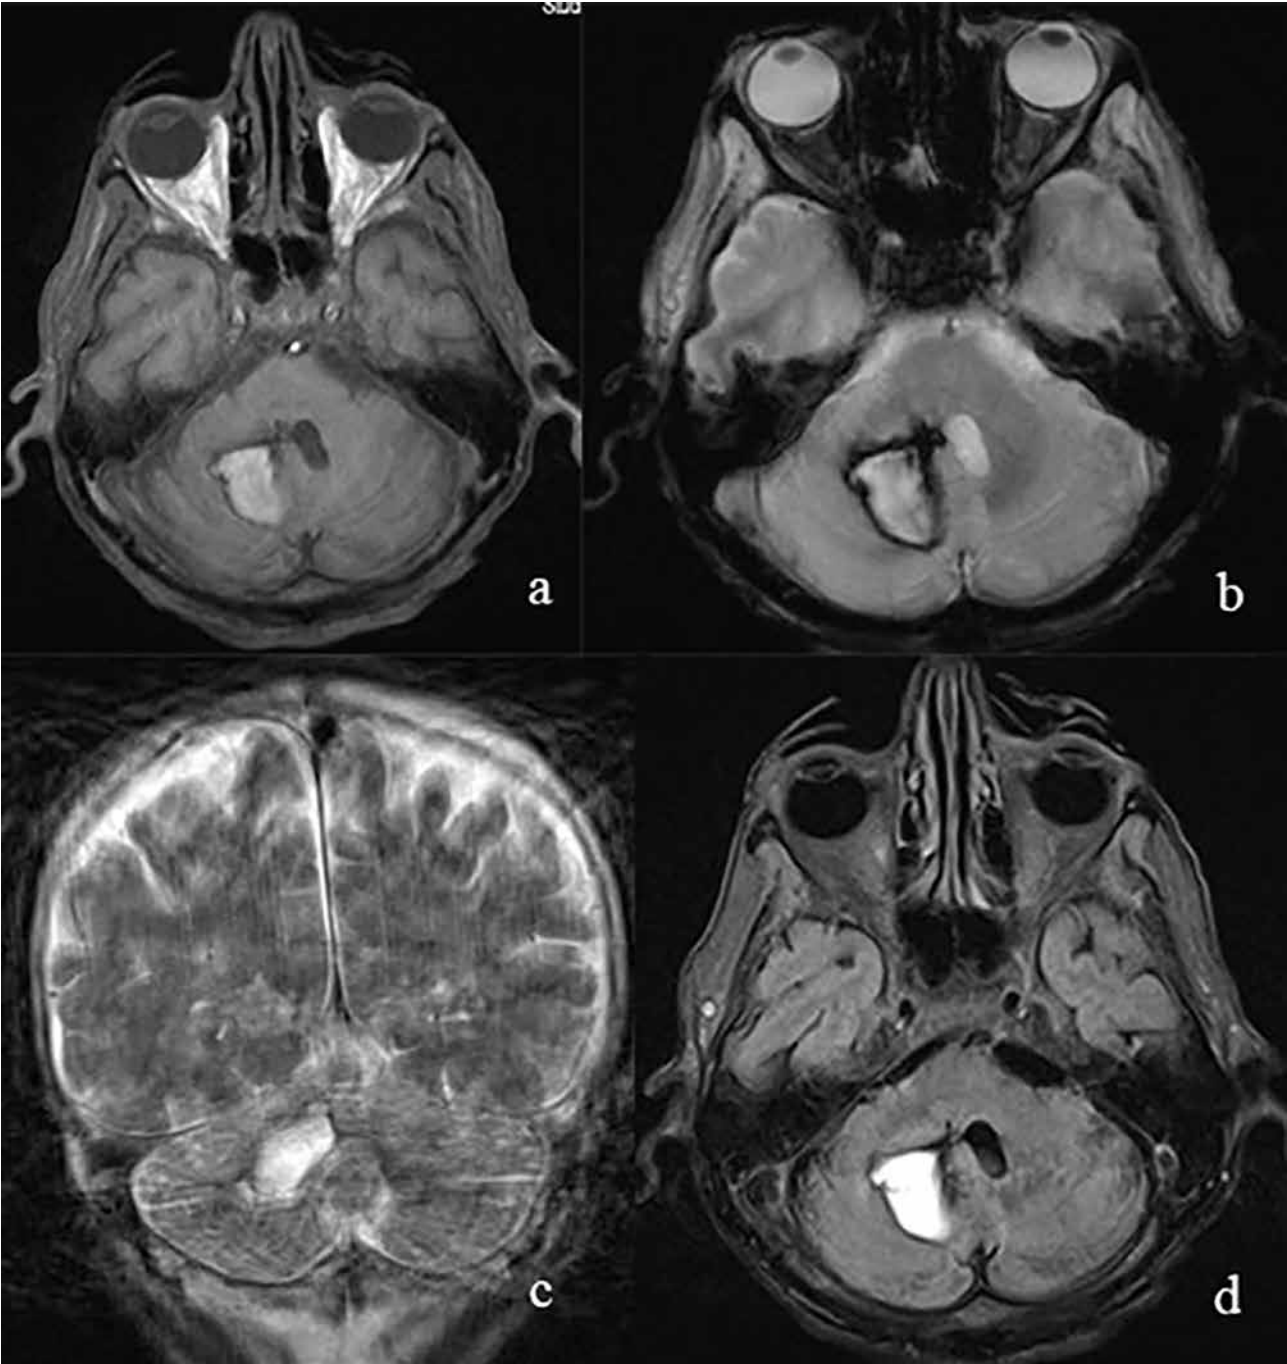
MRI of a non-traumatic haemorrhage at the right cerebellum hemisphere (a -T1W axial; b- T2W fl2d hemo axial; c- T2W coronal (movement artefacts); d- T2W FLAIR axial).
